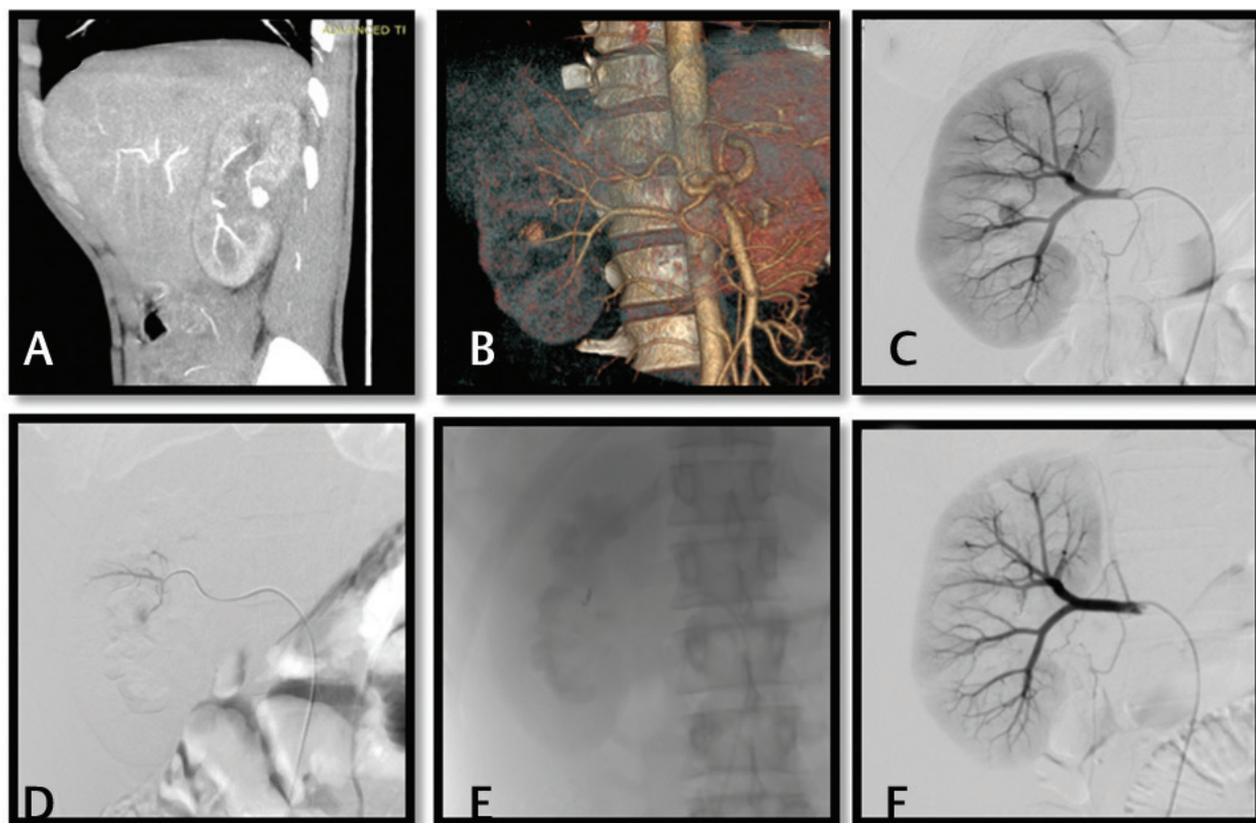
Case of traumatic renal pseudoaneurysm. (A) Computed tomography angiogram showing a narrow neck pseudoaneurysm arising from one of the interpolar branches of the right renal artery. (B) Volume-rendered images showing the pseudoaneurysm. (C) Diagnostic DSA showing the pseudoaneurysm and the artery of origin. (D) Super selective run through microcatheter. (E) Coil placement under fluoroscopy guidance. (F) Post embolization run showing no filling of the sac.
